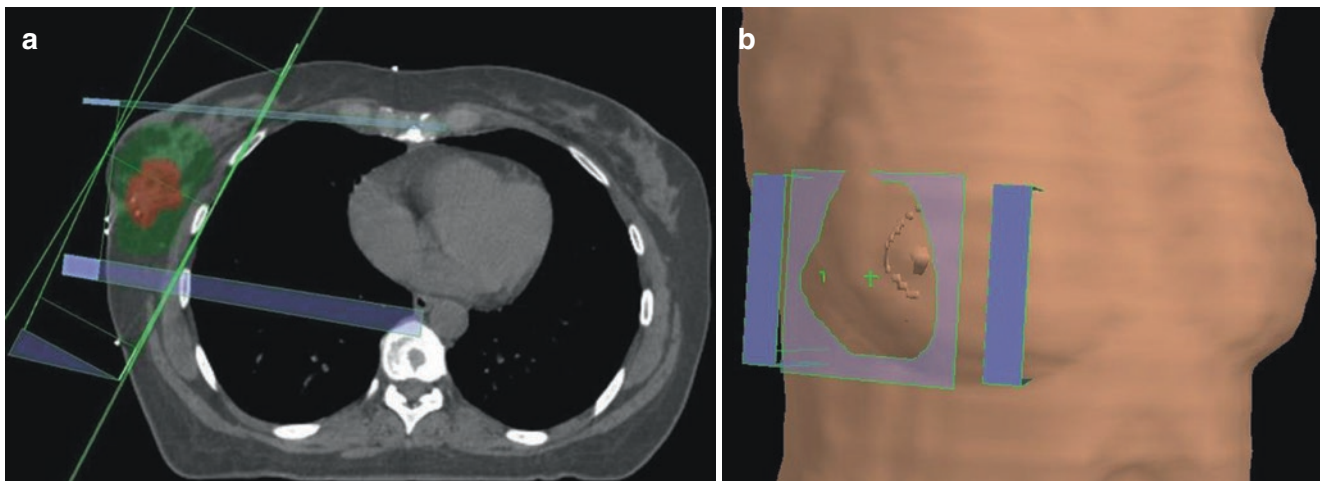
(a) Axial CT image showing the use of two tangent fields with an en face electron field. A lateral wedge has been added to improve dose distribution. The seroma is shaded in orange, and the target volume is
